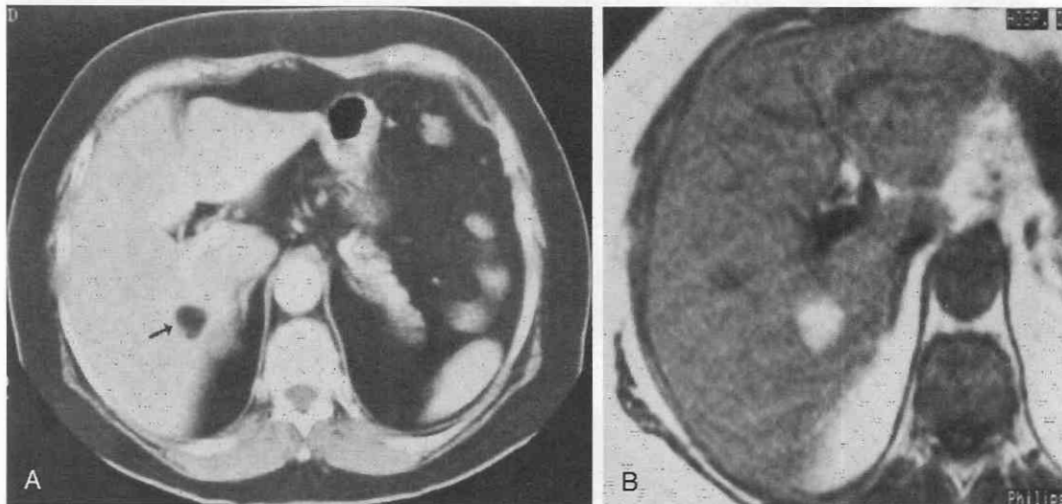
Lipoma of the liver. A, Contrast-enhanced CT scan demonstrates a lesion of low attenuation (arrow), with similar attenuation to subcutaneous and retroperitoneal fat. B, T1-weighted image demonstrates the lesion's high signal intensity, similar to that of other fatty areas. (From Marti-Bonmati L, Menor F, Vizcaino J, et al: Lipoma of the liver: US, CT and MRI appearance. *Gastrointest Radiol* 14:155-157, 1989.)
